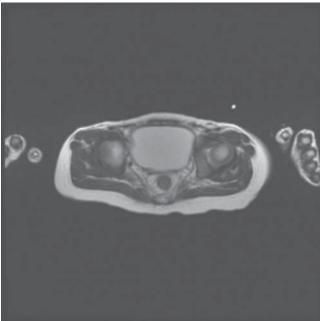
Magnetic resonance imaging performed after anorectoplasty shows an absent uterus and vagina. *Top panel*, sagittal view; *bottom panel*, cross-sectional view. No uterus or vagina was observed in the space between the bladder and the rectum
